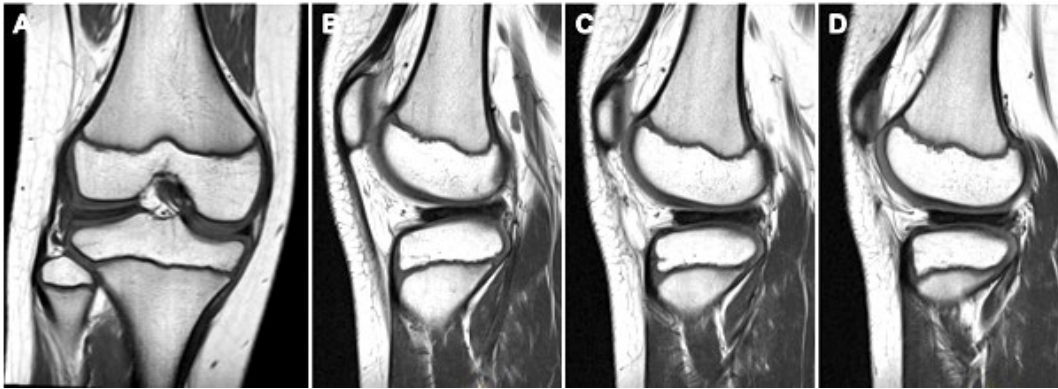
Radiograph features suggestive of a discoid lateral meniscus
